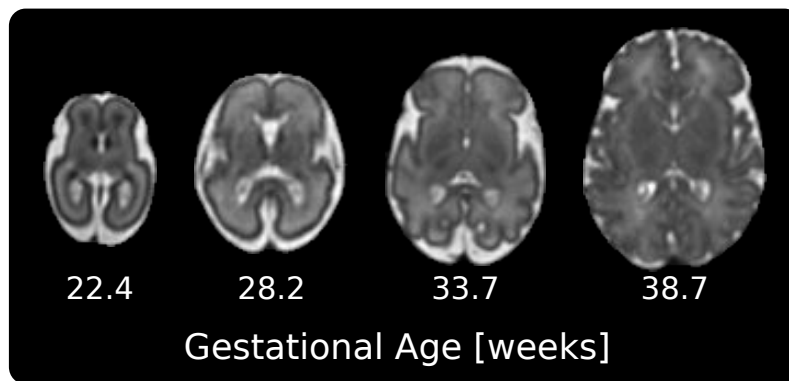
Cortical folding visualized through magnetic resonance imaging. These *in utero* magnetic resonance images show the rapid convolution of the fetal brain in the third trimester. The cortical grey matter is seen as a dark ribbon on the surface of the brain.
